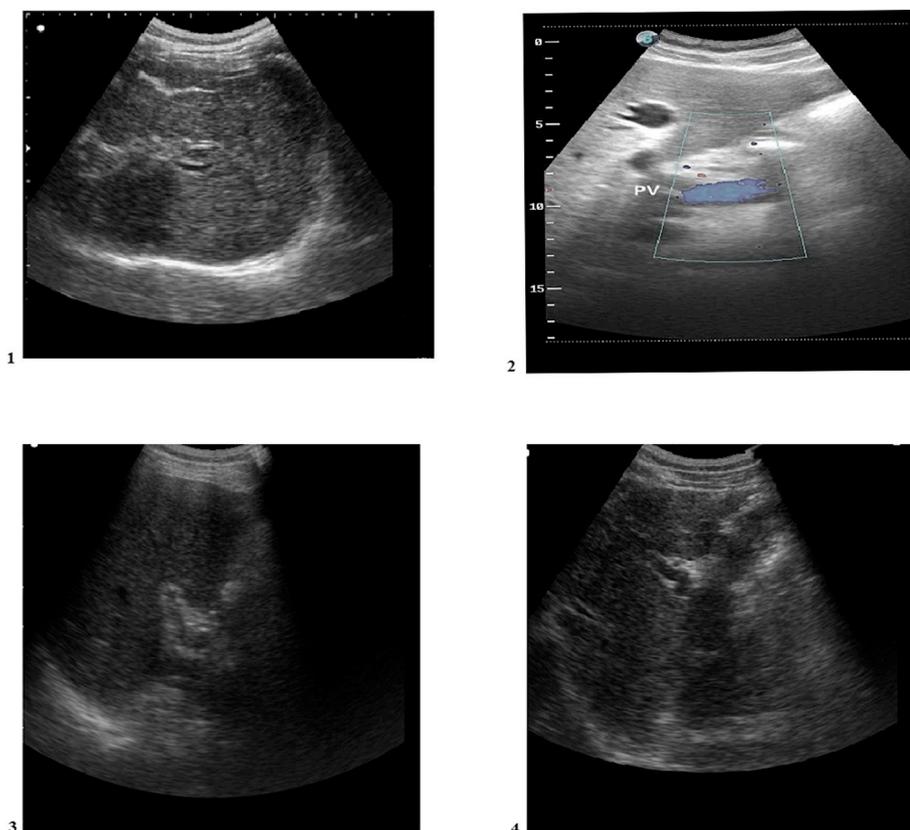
1: Abdominal ultrasonography reveals cirrhotic liver with complete portal vein thrombosis. 2: Color Doppler ultrasonography reveals portal vein thrombosis. 3: Abdominal ultrasonography reveals complete portal vein recanalization after treatment with rivaroxaban. 4: Abdominal ultrasonography reveals complete portal vein recanalization after treatment with rivaroxaban.
